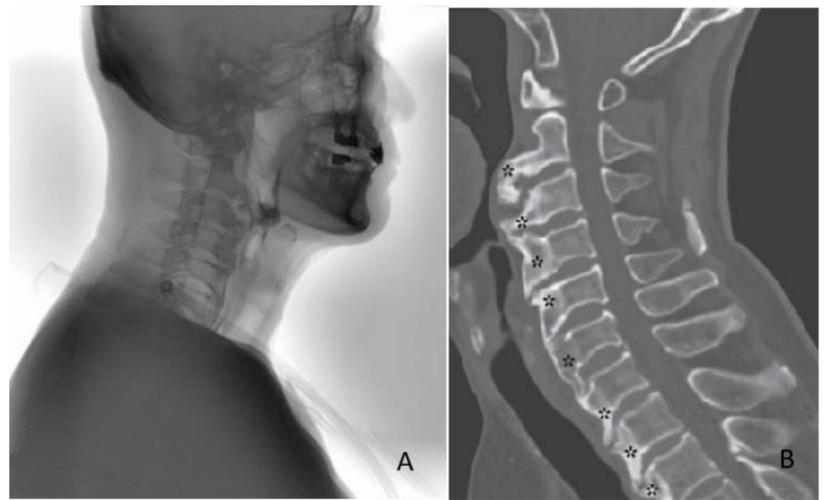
A. VFSS image and B. CT image of the first case patient.
